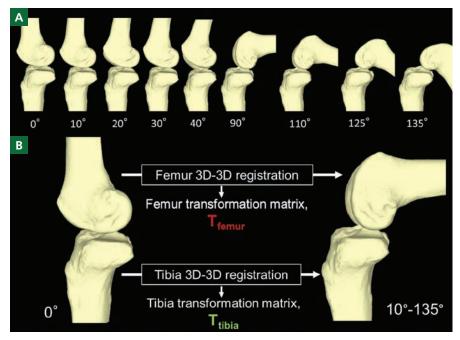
A, Three-dimensional (3D) computed tomography (CT) models in the tested flexion angles. B, A representative 3D CT model outlining the 3D-3D registration in preparation for subsequent point matrix incorporation on the femur and tibia.
